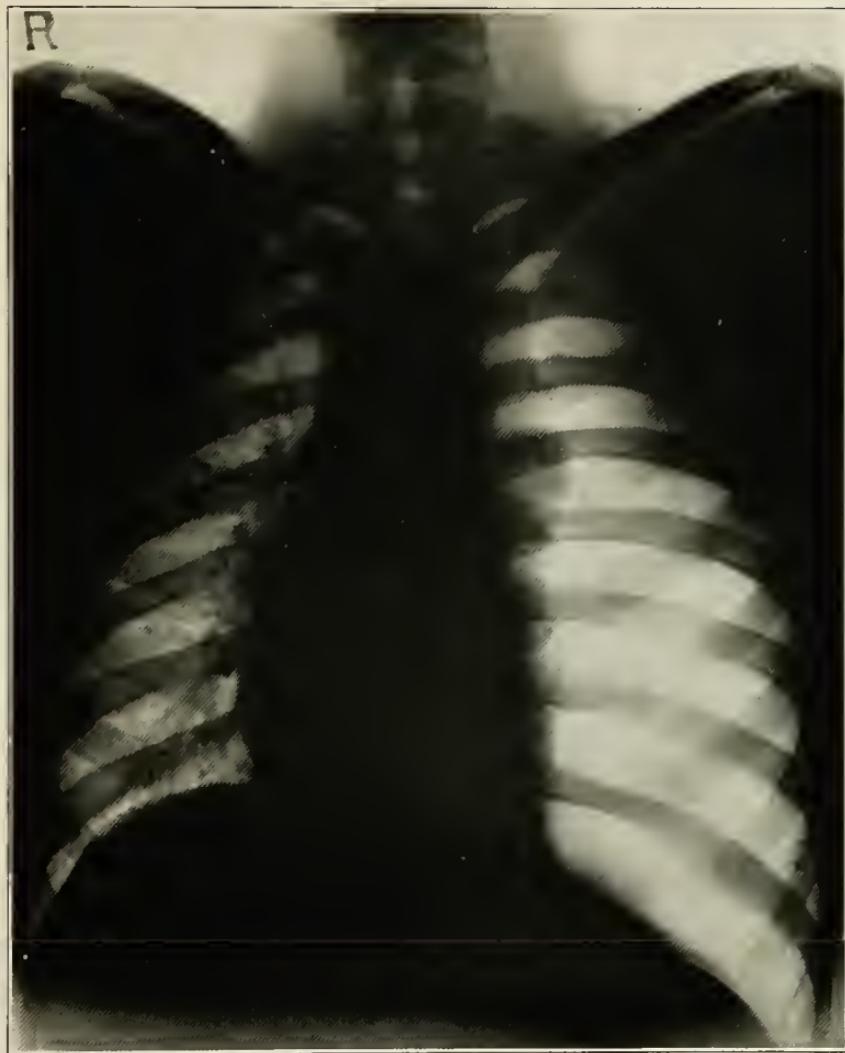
Nov. 24, 1921. X-Ray of the thorax showing a total collapse of the left lung with the displacement to the right of the heart and trachea.
